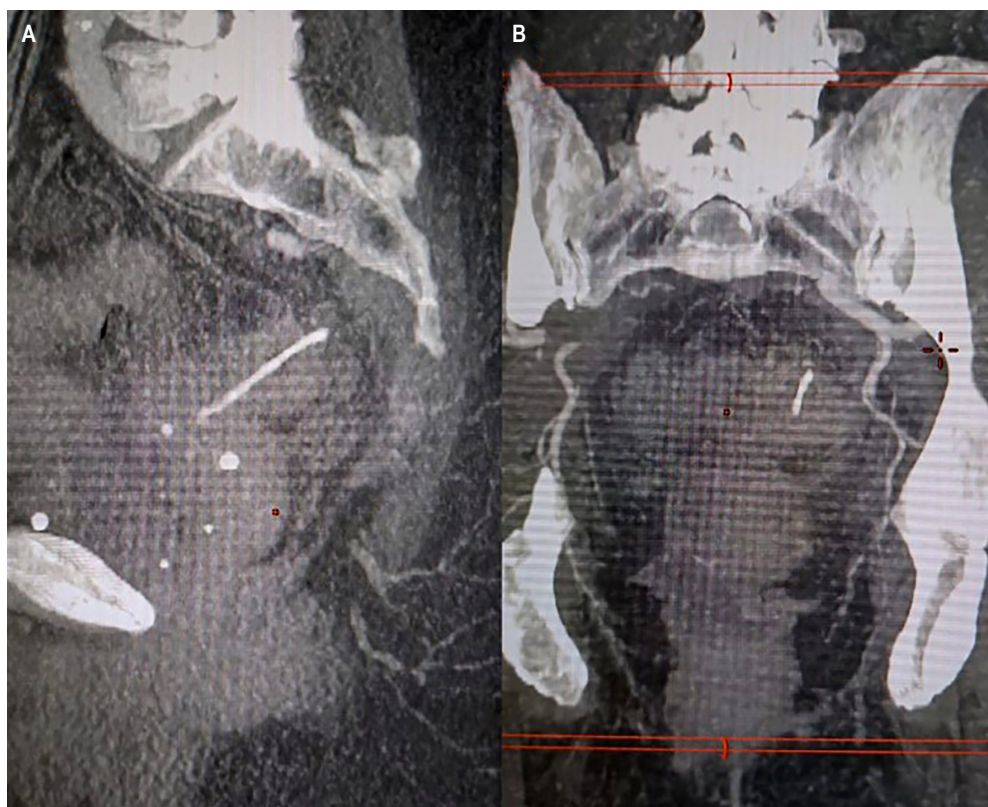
Abdominal and pelvic CT scan showing signs of hollow intestinal loop rupture, free fluid, inflammatory changes in the peritoneum, and a linear hyperdense structure in the left adnexal region and sigmoid colon. Image courtesy of the Radiology Department, Fundación Cardiovascular de Colombia. Bucaramanga, Colombia.
